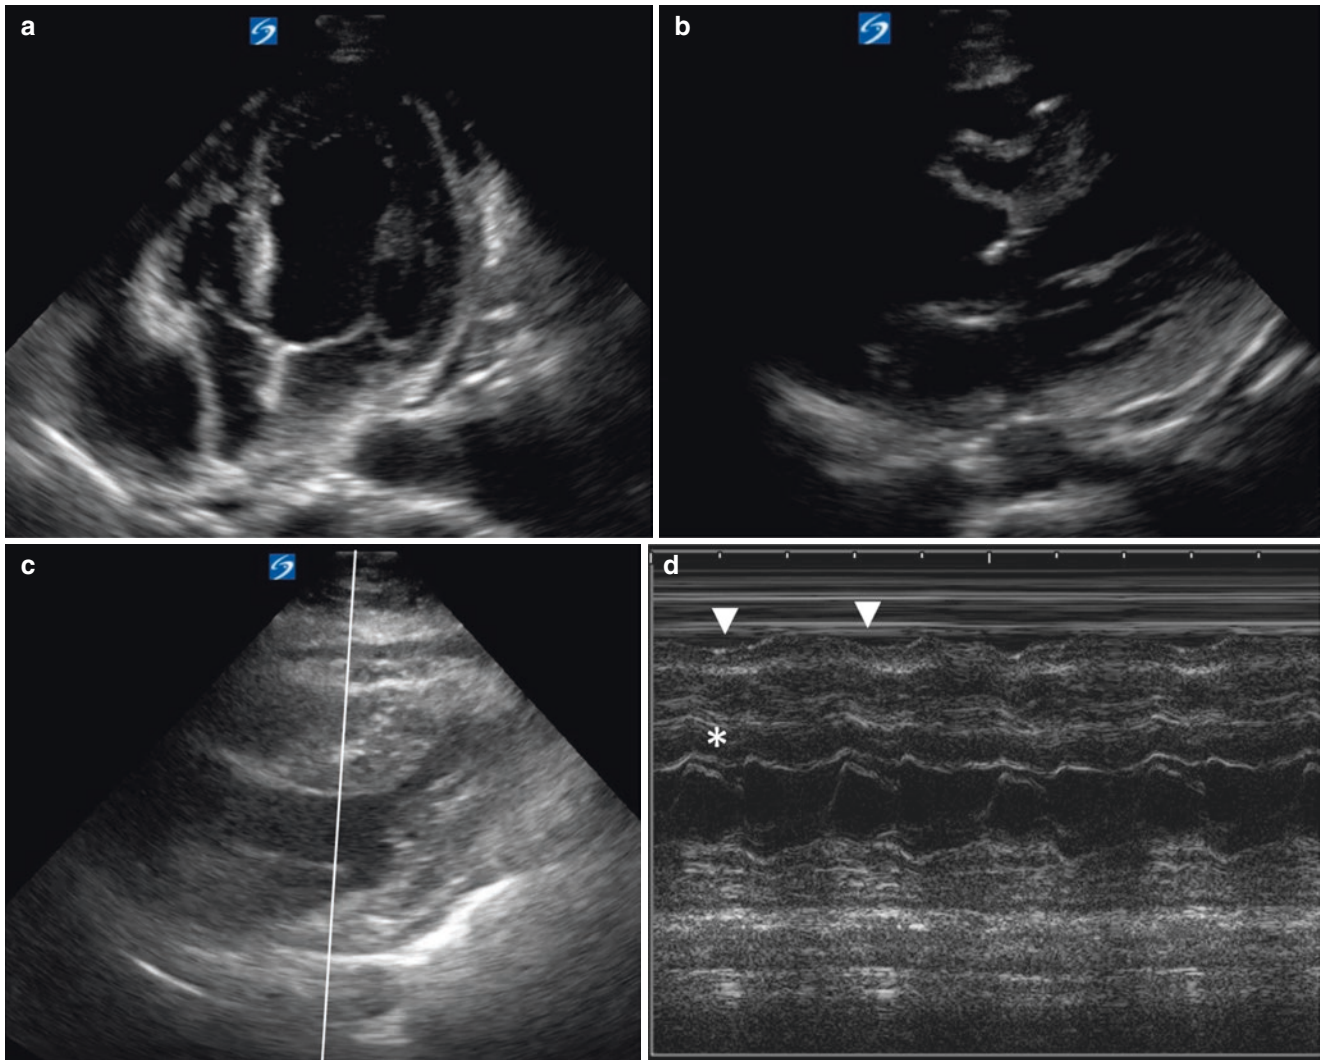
Echocardiographic signs of tamponade. (a) Right atrial inversion (RAI) seen during systole (MV closed) in the apical four-chamber view, a more sensitive but less specific sign. (b) Diastolic right ventricular inversion (RVI), a more specific sign of cardiac tamponade.
